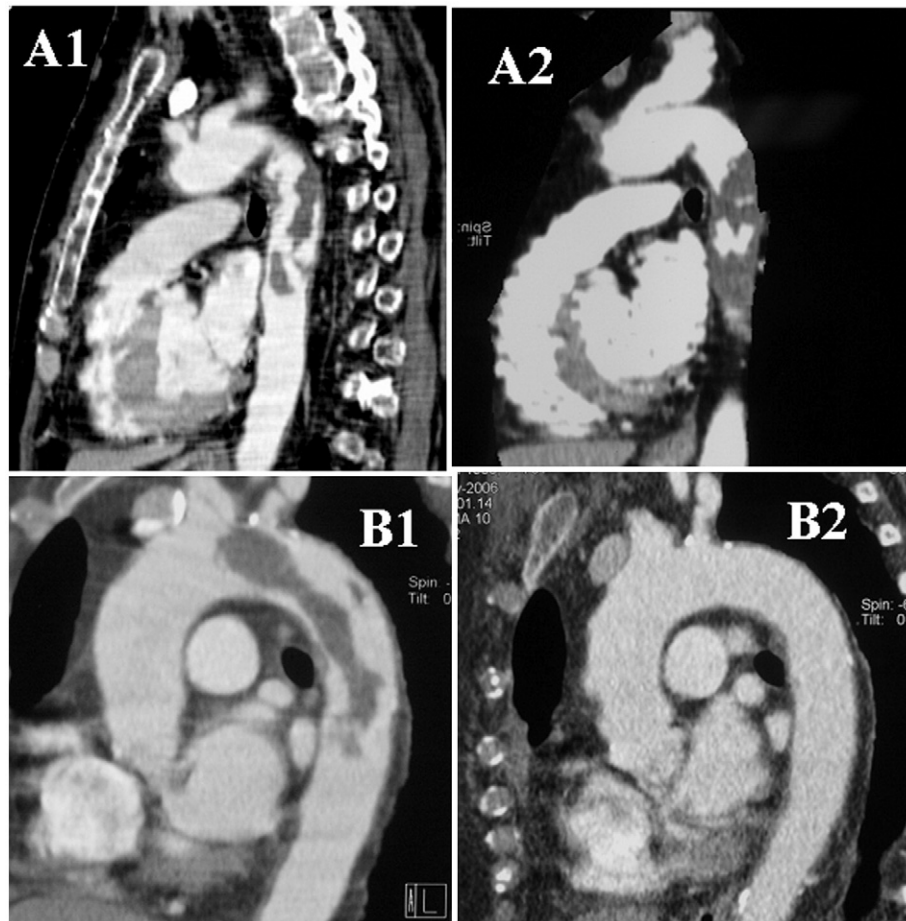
Thoracic CT of our two patients with intra-aortic mass. A1: patient 1 at admission; A2, patient 1 two months later. B1: patient 2 at admission; B2, patient 2 after thrombolysis.
